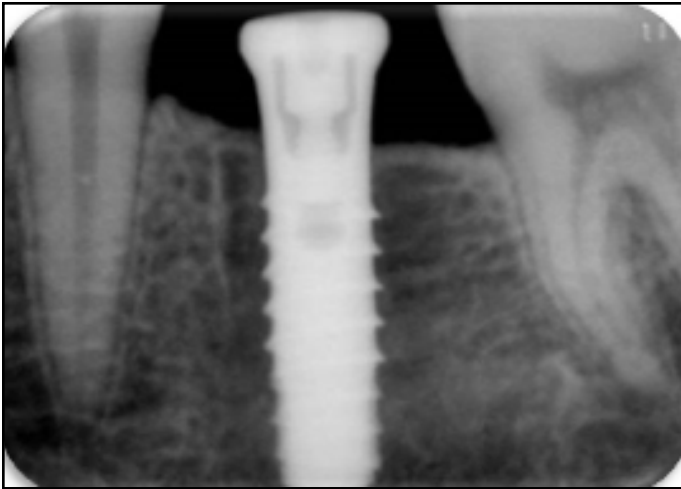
Baseline radiograph.
